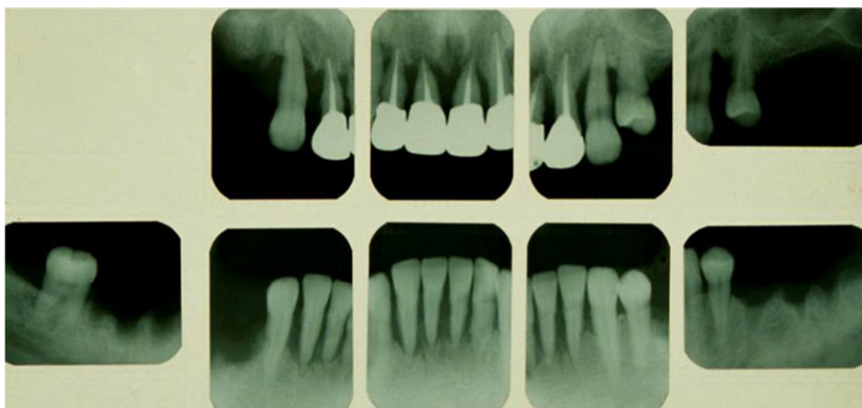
Full-mouth radiographs of patient's mother taken October 15, 1991.
